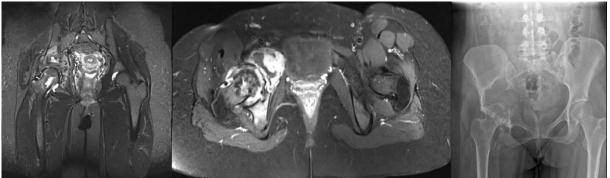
The imagings of the pelvis lesion in MRI scan and X-ray scanning
